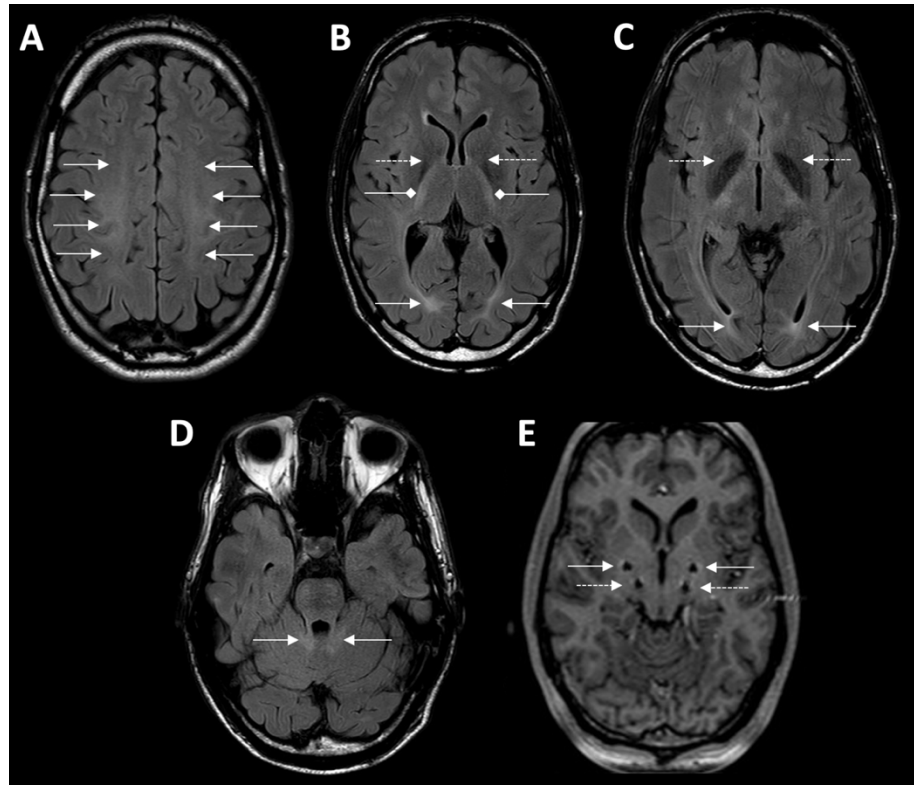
Magnetic resonance imaging (MRI). (A-D) MRI of the patient at the age of 27 years. Axial T2-weighted (fluid-attenuated inversion recovery) images are shown. Imaging demonstrated symmetrical T2-hyperintense cerebral demyelination involving central (white arrows in A) and occipital (white arrows B and C) white matter, the internal capsule (white square-ended arrows in B), and the cerebellar peduncles (white arrows in D). Moreover, symmetric T2 hypointensities in the globus pallidus were observed (white dotted-line arrows in B and C). (E) Post-surgery MR imaging of the four deep brain stimulation electrodes bilaterally in the globus pallidus internus (GPI, white arrows) and nucleus ventralis intermedius (ViM, white dotted-line arrows).
